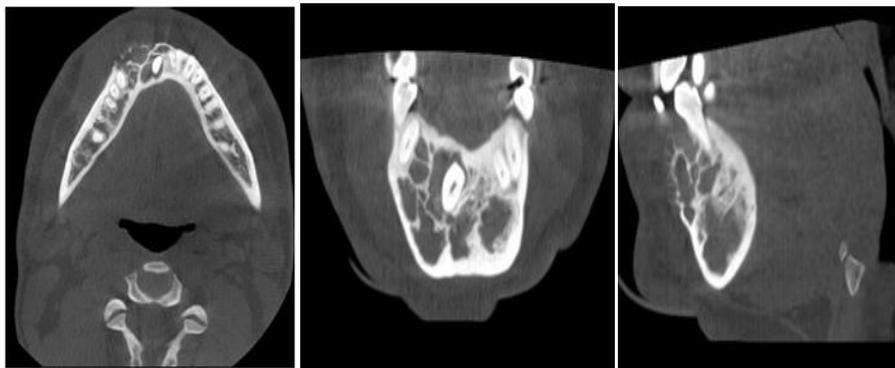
CBCT images showing multilocular lesion in the anterior mandible with faint septa extending beyond the peripheral margin of the lesion at right angles
